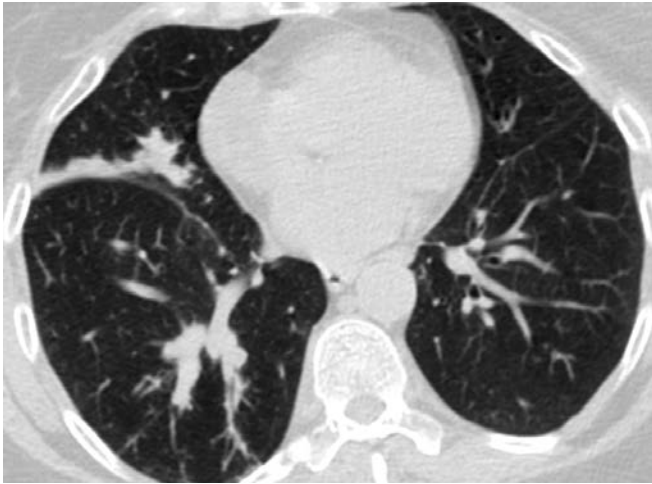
CT chest showing inspissation of bronchi in a patient with allergic bronchopulmonary aspergillosis
